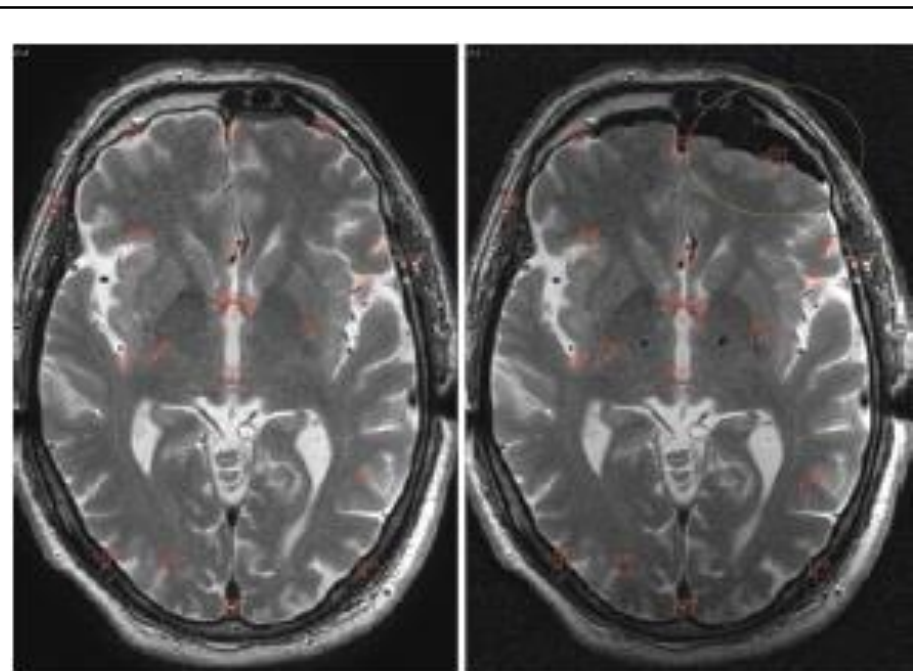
Comparison of unique structures using ROIs. A T2-weighted axial MR image is obtained at 2 separate time points during surgery. On the left is the pre–electrode placement image used for targeting. On the right is the post–bilateral electrode placement image. Each red outline is a specific ROI identifying a structure used to calculated shift. Obvious shift can be noted in the left frontal lobe surface (circled).
